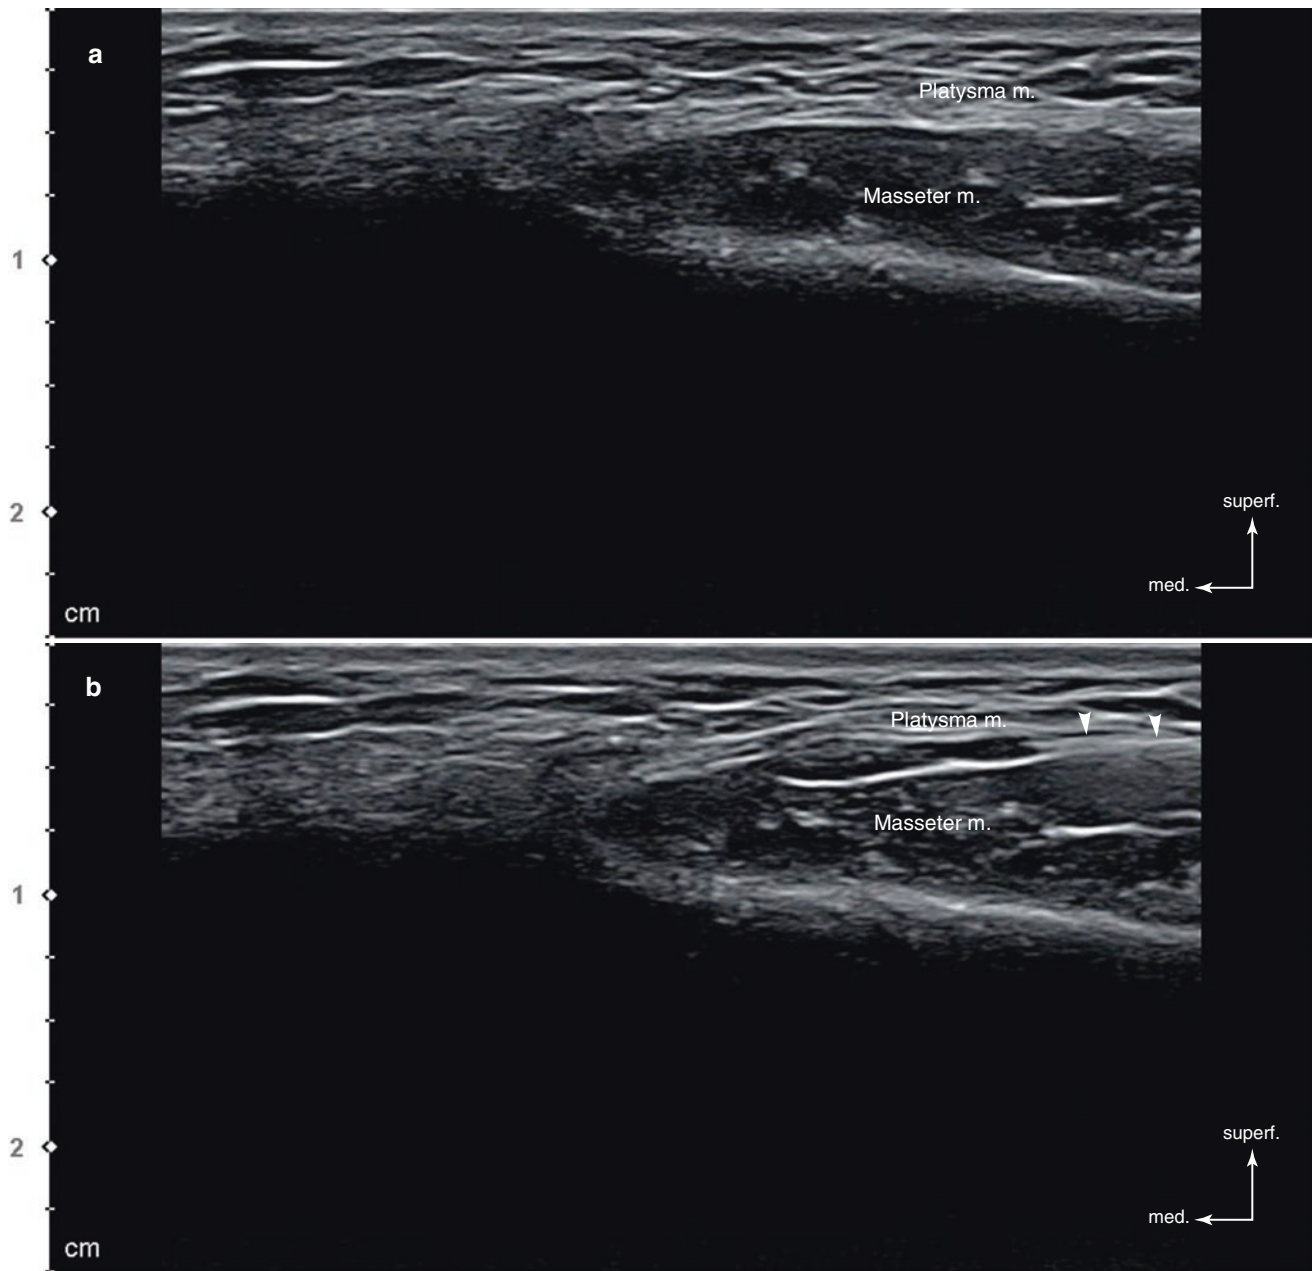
Ultrasonography-guided botulinum toxin injection to the platysma muscle (in-plane). (a, b) B mode (transverse view, 15 MHz by linear transducer) (white arrowheads: injection needle). (Published with kind permission of © Ji-Soo Kim 2020. All Rights Reserved)
